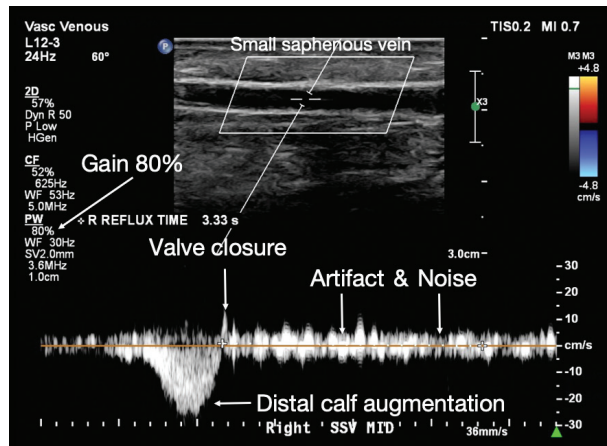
Pulsed-wave Doppler waveform demonstrates artifact and noise. These artifacts are reminiscent of excessive pulse-Doppler gain set at 80% and movement of the transducer. The operator measured the duration of reflux as 3.3 seconds, which is completely erroneous. This vein does not present evidence of reflux.
